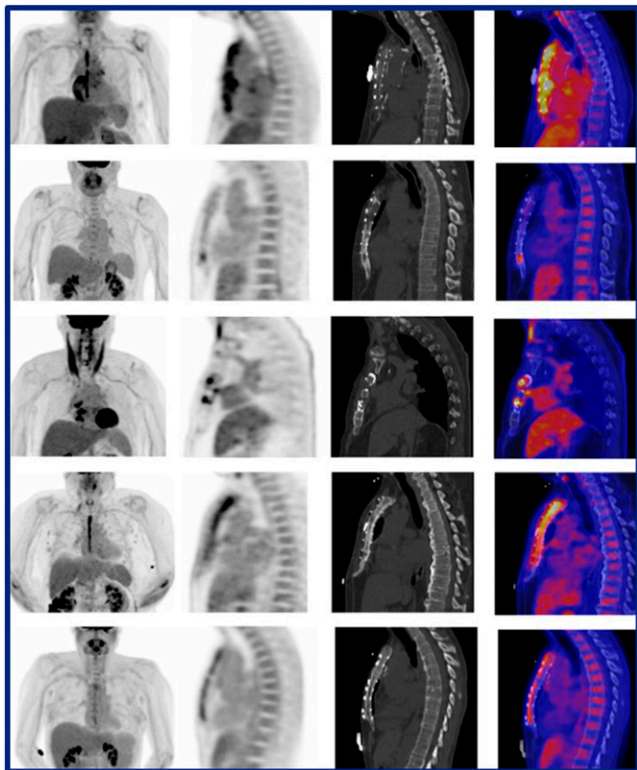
Imaging results after median sternotomy, showing (top to bottom): soft-tissue extension, focal uptake, sternal wire uptake, diffuse high-grade uptake, and diffuse low-grade uptake on (left to right): maximum-intensity projection, ^{18}F -FDG PET, CT, and ^{18}F -FDG PET/CT imaging for assessment of sternal wound infection. PET/CT was more specific than CT alone for the presence of infection, and varying patterns of uptake were identified. These patterns can affect interpretation, as can timing of imaging after surgery.
